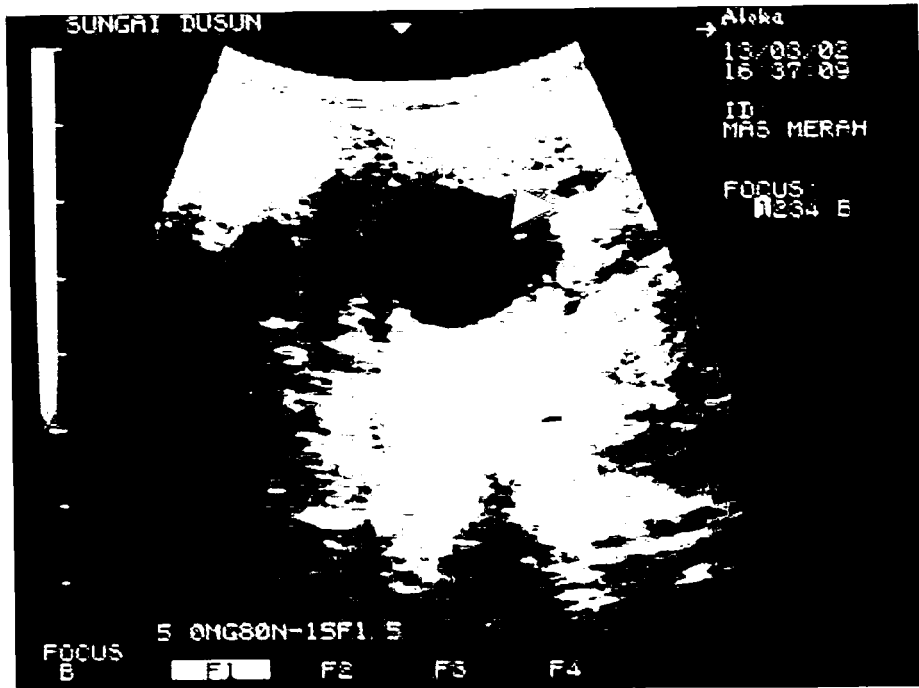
Ultrasound images of follicular change observed in Mas Merah during behavior that resulted in progressive resistance towards Ara. Note increased echogenicity of follicle (upper image, 13 March; arrow) and follicle shape change (lower image, 14 March) that suggests follicular lutenization and increasing progesterone influence that would explain the observed resistant behavior.
